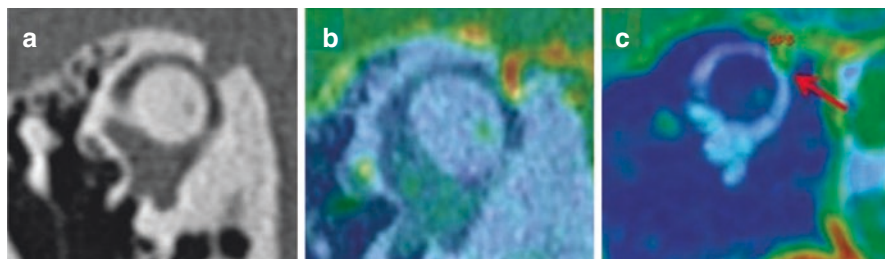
(a) high-resolution computed tomography (HRCT) Pöschl plane. “Cookie bite” aspect, SSCD by SPS (length measured at 1.7 mm). (b) Fusion between HRCT and 3D T1 weighted enhanced sequence. (c) Fusion between 3D T1 weighted enhanced and T2 HR sequences. Compression effect on the SSC (arrow). *SSCD* superior semicircular canal dehiscence, *SPS* superior petrosal sinus
